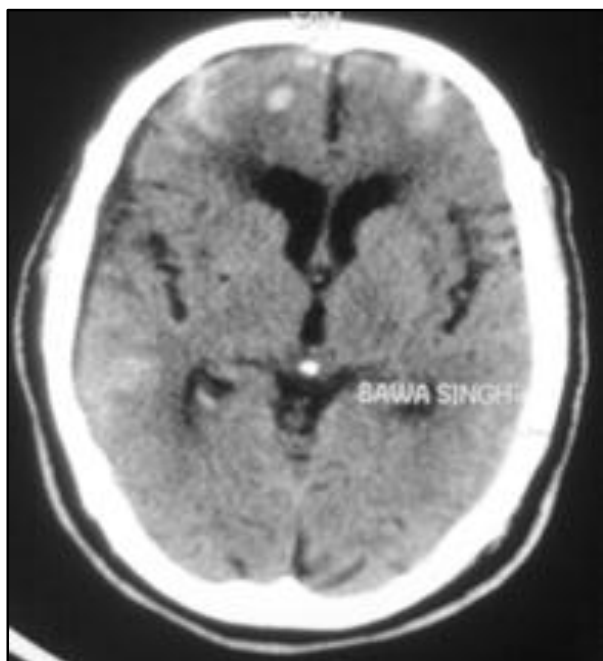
CT Axial Image showing SAH Frontoparietal Sulci with Haemorrhagic Contusion-Frontal Lobe
